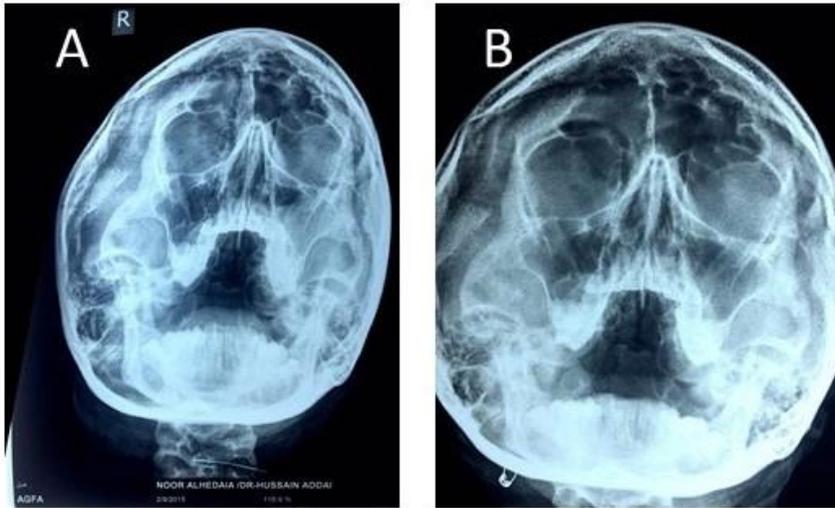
X-ray of maxillary sinuses. A- before treatment, B- after treatment.
